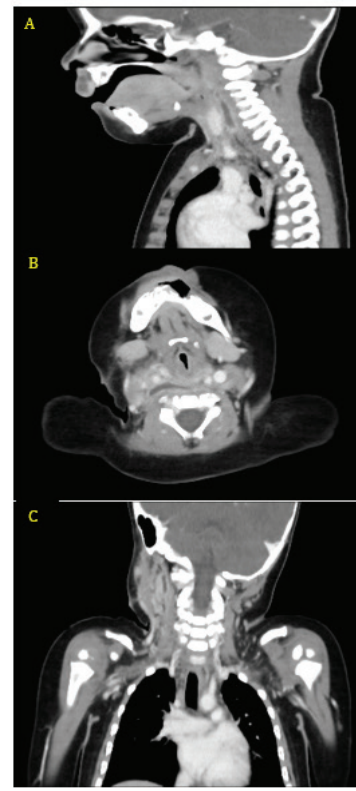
Contrast-enhanced cervical CT. A: sagittal view. B: axial view. C: coronal view.
